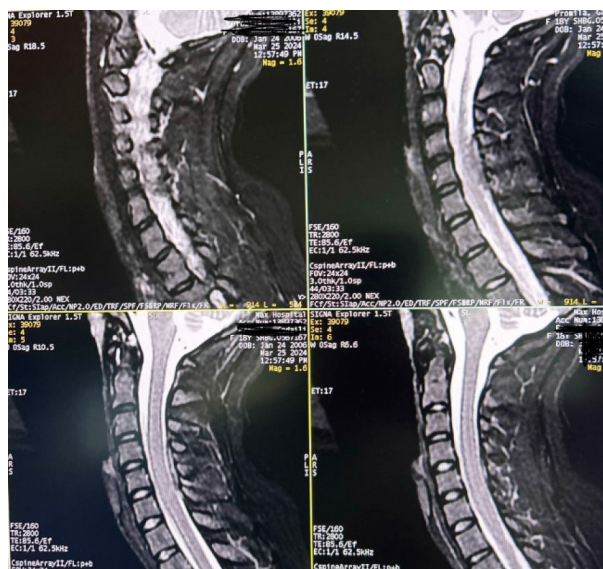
MRI Cervical with Contrast
